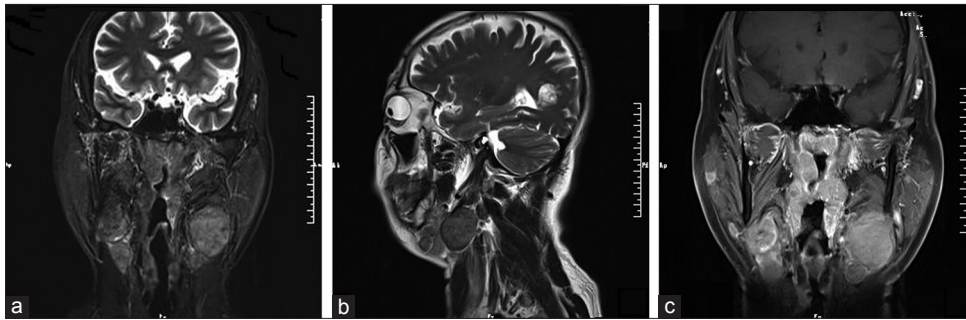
Imaging findings of a 55-year-old man (patient 9): (a) T2-weighted coronal and (b) T2-weighted sagittal MRI scans showed the lesion was located in the right nasopharynx and bilateral neck. There was no edema surrounding the mass. (c) The lesion was homogeneously enhanced, following administration of the contrast agent. MRI: Magnetic resonance imaging.
